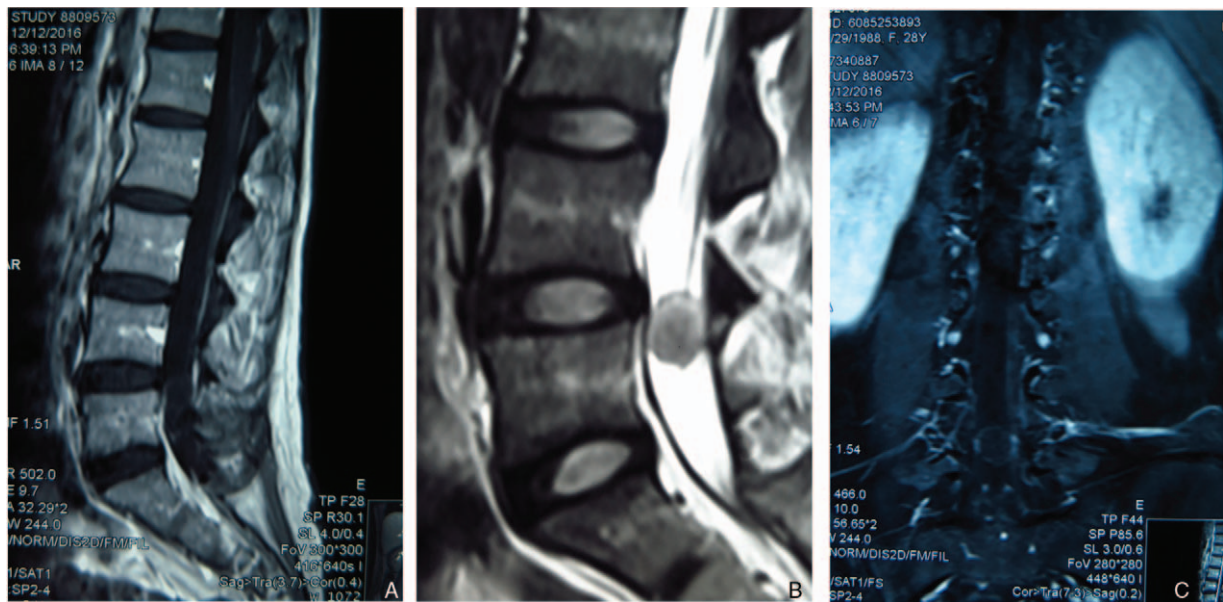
Preoperative magnetic resonance images (MRI). Sagittal MRI T1WI image shows slightly low, equal, and uneven equal-low signals (A). Sagittal MRI T2WI image shows slightly higher, equal, and uneven equal-high signals (B). Axial anatomical Gd-DTPA-enhanced image shows a thin-rim enhancement (C).
